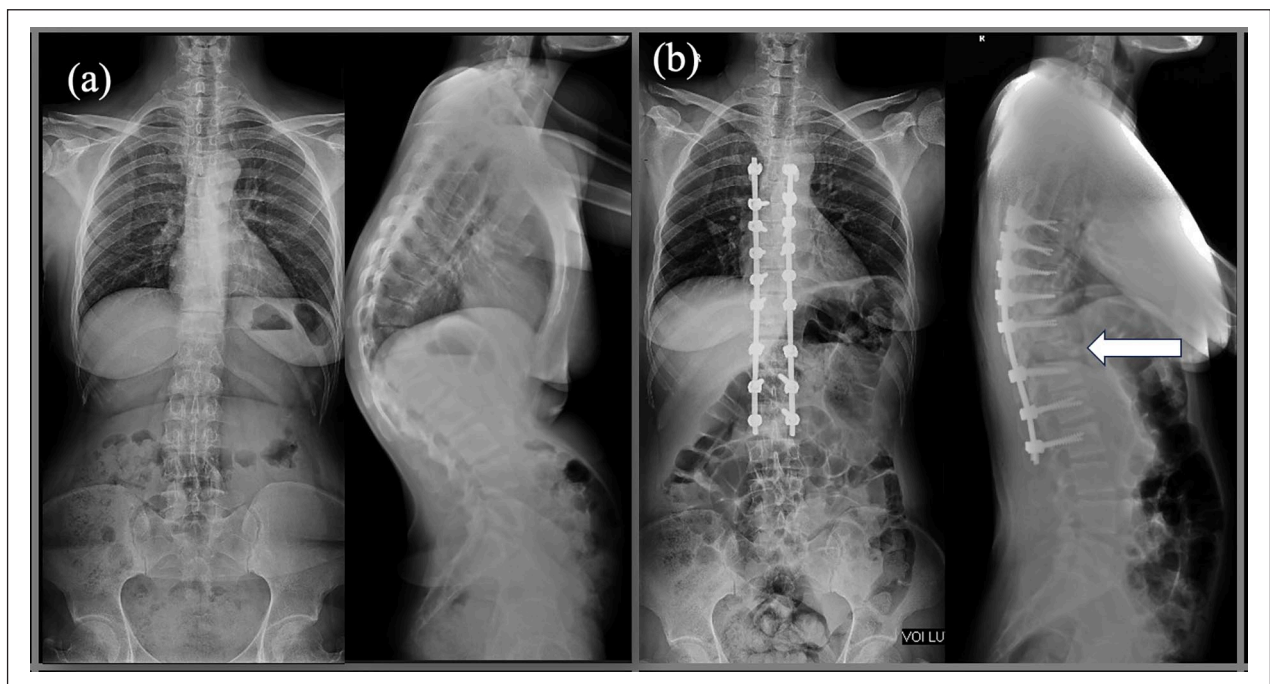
(a) Radiographs of an adult patient with neglected type II SD. The thoracic kyphosis measures 77°, with an apex at T11. Preoperative bolster radiographs to assess curve flexibility showed significant rigidity, and a pedicle subtraction osteotomy was performed (arrow) at the apex (T11) to correct the deformity (b).
